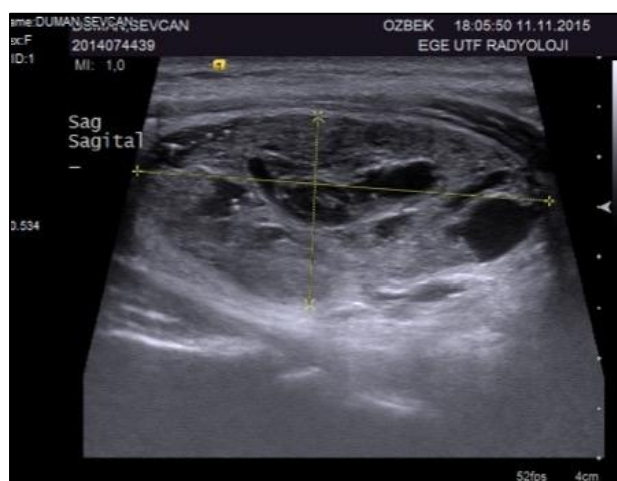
Thyroid ultrasound showing nodule at right lobe with a diameter of 43x18x28 mm.
